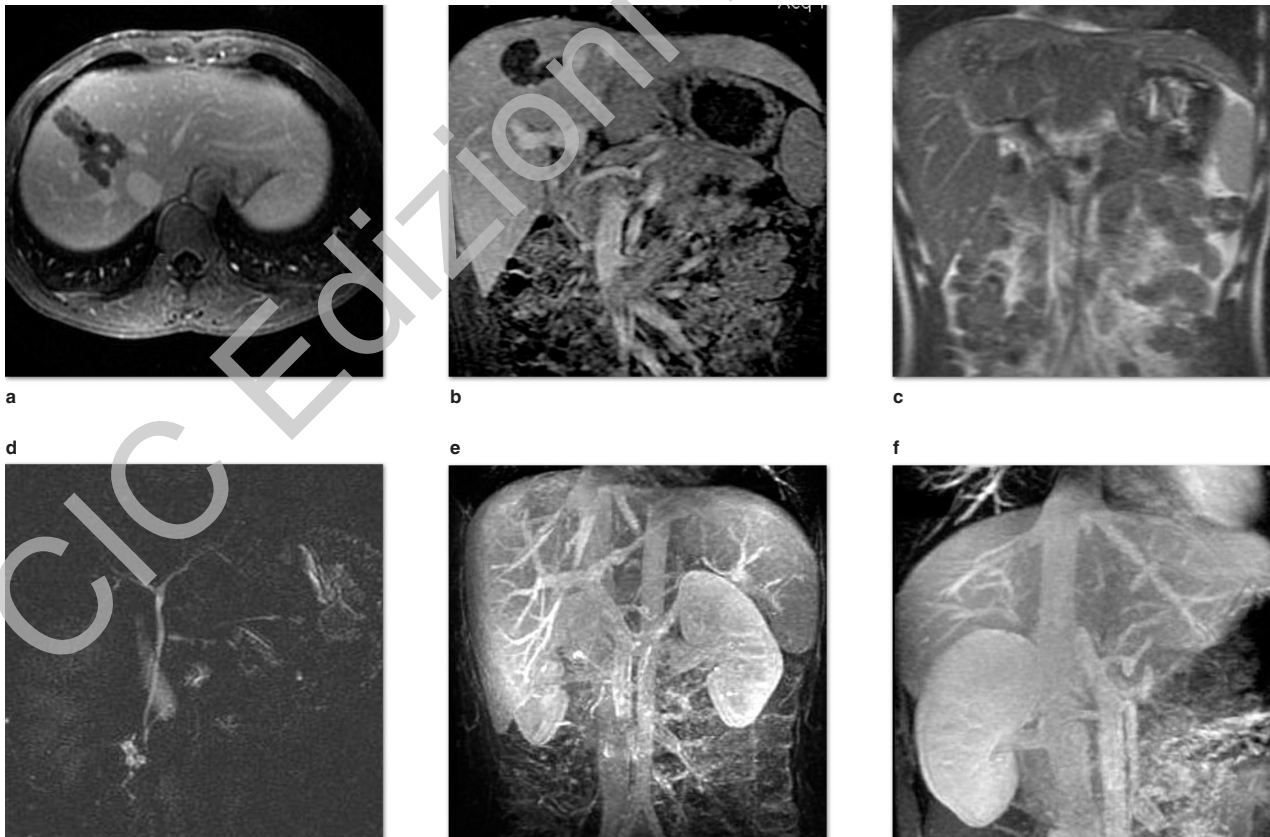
a-f - Angio-MR study performed 2 months after the treatment demonstrates the residual necrosis in the RF treated area that appears ipointense in the T1 gradient-echo sequences (a, b). The coagulative necrosis is dark on T2-weighted images (c). No fluid collection were seen. Magnetic resonance cholangiopancreatography demonstrates normal findings of biliary tree (d). At magnetic resonance angiogram (e, f) portal vein and sovrahepatic vessels are normal.
